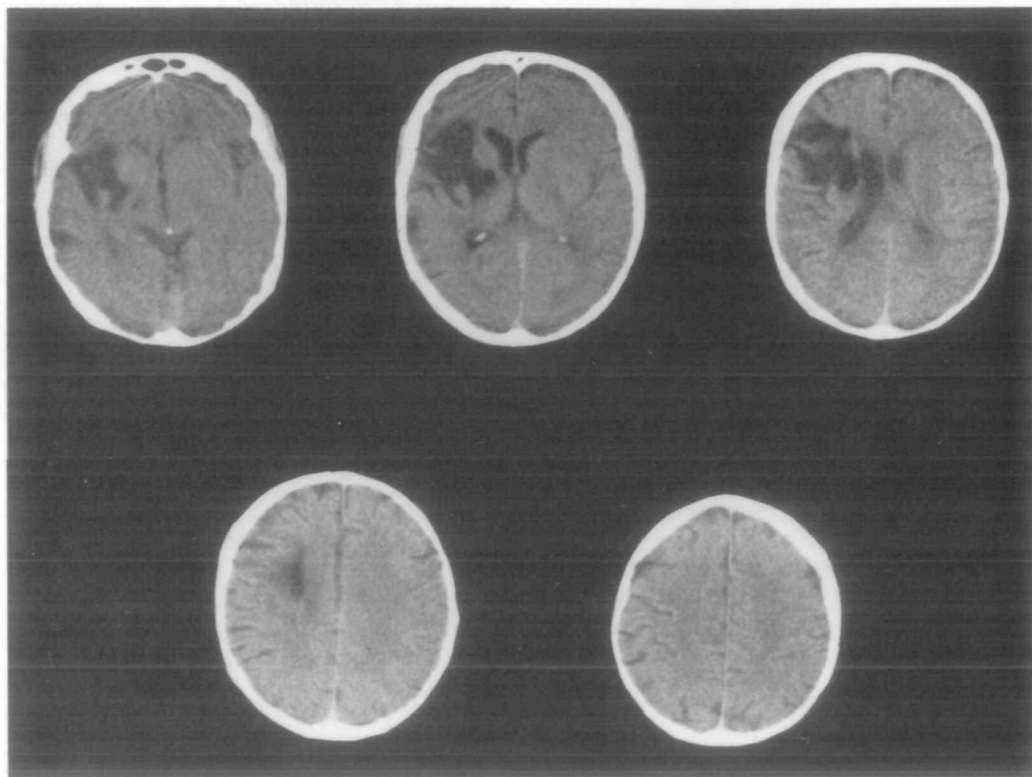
CT scan of *Case 1* performed 9 months after onset. The structures involved by the lesion are discussed in the text.
